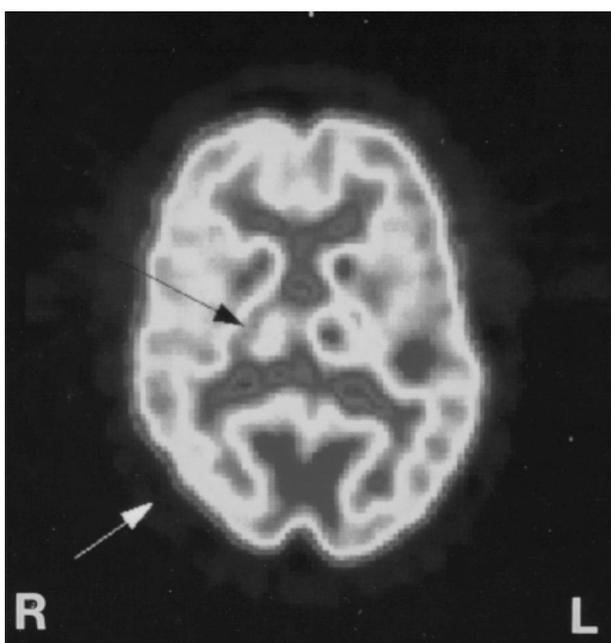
FDG PET scan showing right thalamic (black arrow) and right parietal lesions (white arrow).
